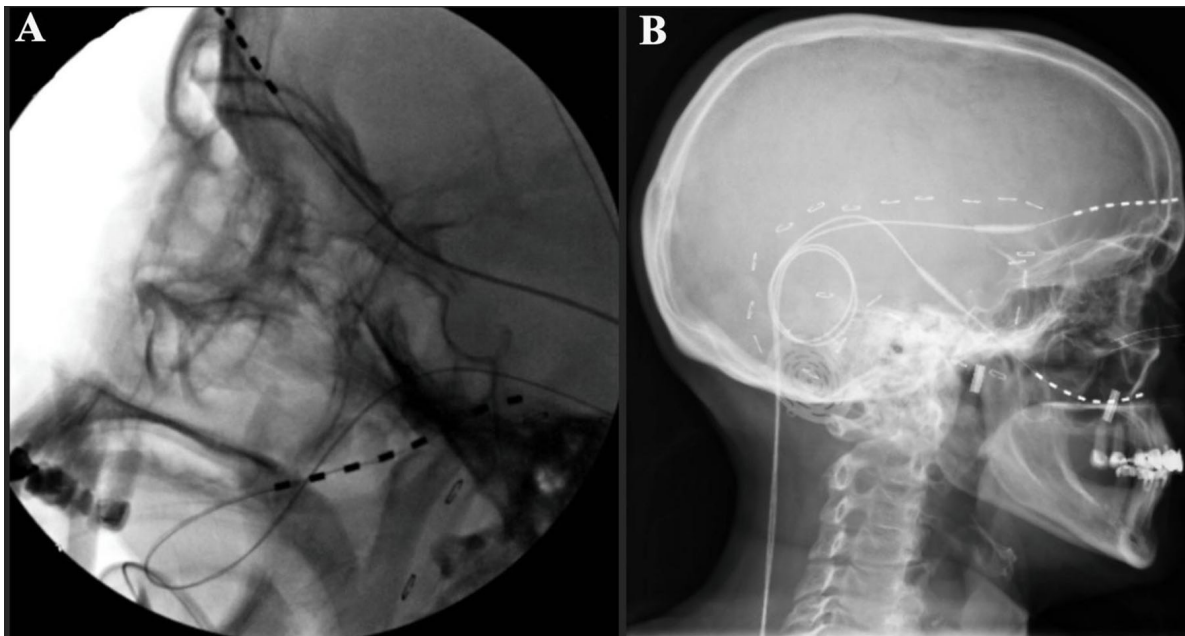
(A) Intraoperative lateral skull radiographs showing placement of a percutaneous trigeminal ganglion lead through the Foramen Ovale (inferior). (B) Percutaneous lead placement to cover the V1 (superior) and V2 (inferior) segments of the trigeminal nerve.
